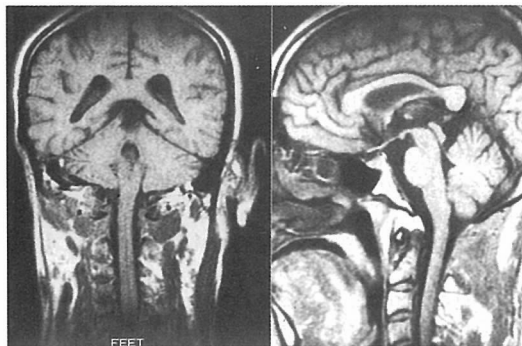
Postoperative MRI (case 1). The tumor is completely removed.
